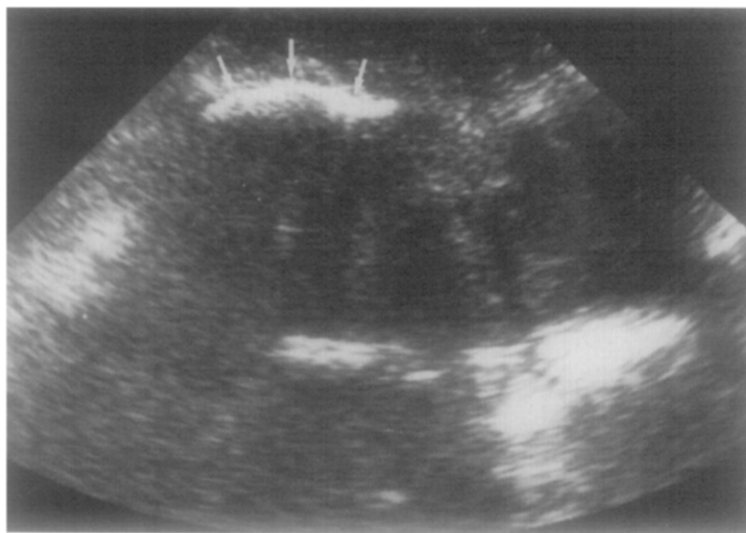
Ultrasonography revealed curvilinear, echogenic shadowing foci (arrows), originally interpreted as calcifications, that proved on pathologic examination to be fetal skull parts.
